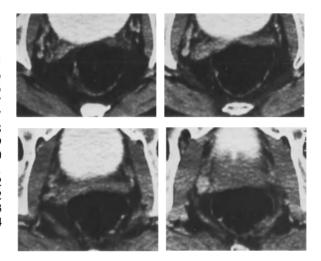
CT of the pelvis. The enhanced venous plexus is shown posterior and lateral to the bladder
